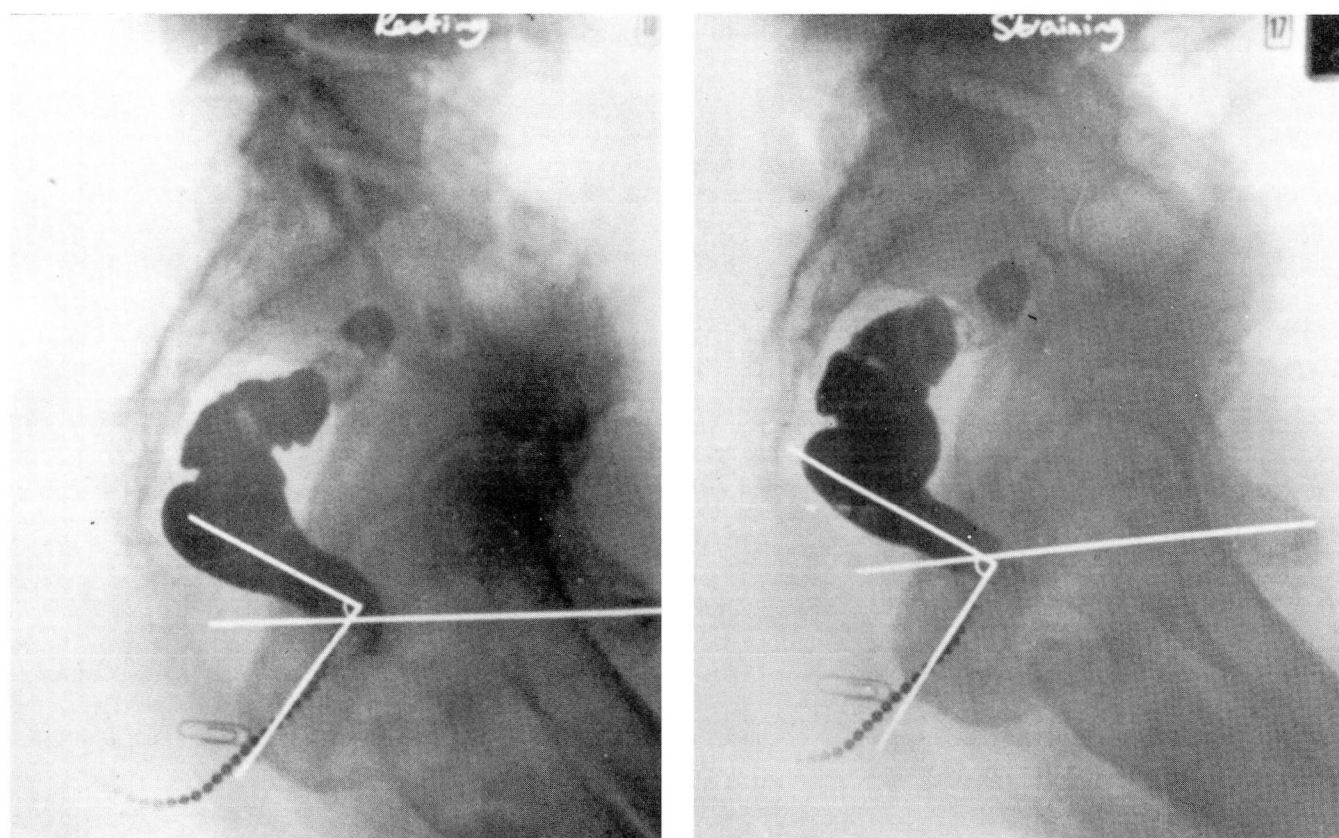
Lateral radiographs of the anorectum (proctography) in a normal subject at rest (left) and while straining (right). The anorectal angle is defined by a line drawn along the rectum and a beaded chain in the anal canal. The pelvic floor is defined by a line drawn from the symphysis pubis and the tip of the coccyx. Courtesy of Dr. N. W. Read. (Wald A. Abnormalities of anorectal function. [In] Cohen S, Soloway RD, eds. Functional Disorders of the Gastrointestinal Tract. New York, Churchill Livingston, 1987, pp 121–138. Reprinted by permission.)
